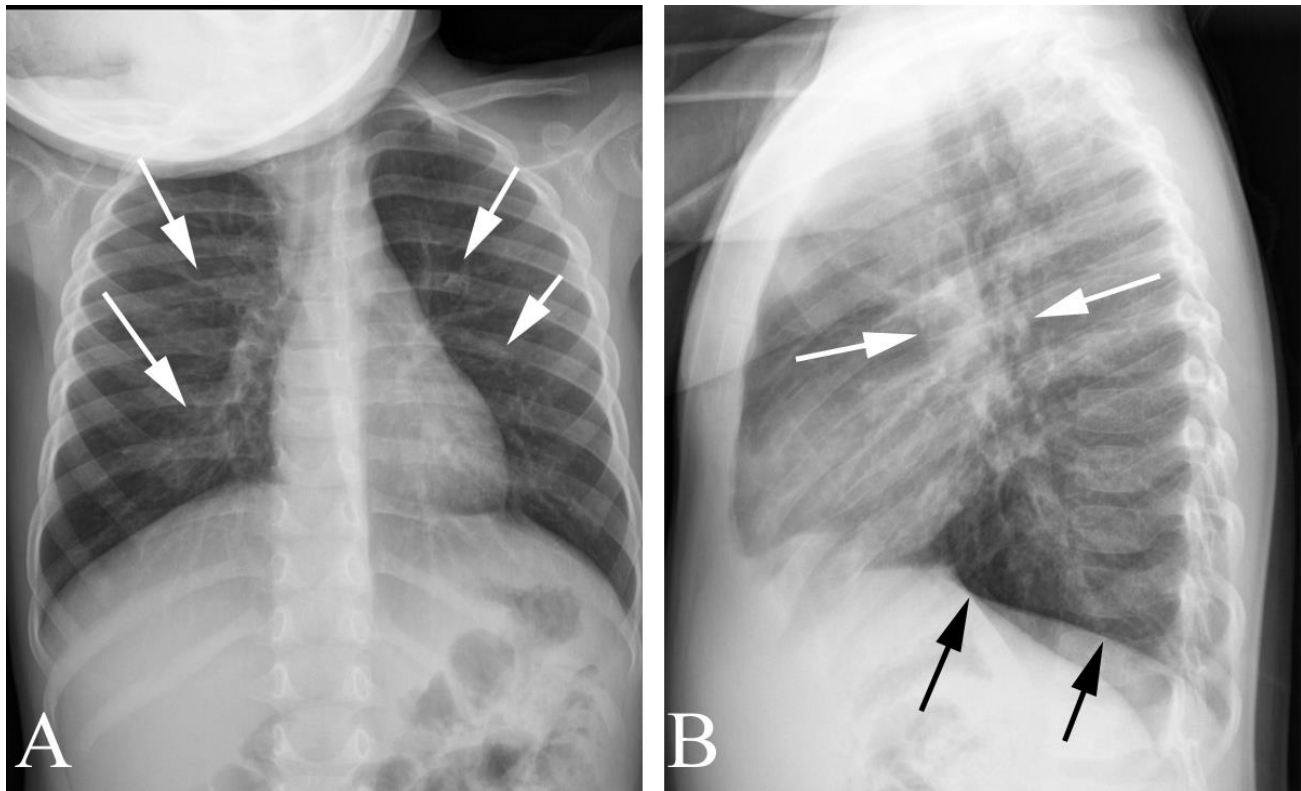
Interstitial pattern in a 2 year old with cough, shortness of breath, and likely viral pneumonia. A. Frontal chest radiograph shows streaky densities radiating from the hila (arrows). B. Lateral chest radiograph shows hyperinflation of the lungs with flattening of the diaphragm (black arrows) along with prominent hila (white arrows). The child’s symptoms resolved without antibiotics.
